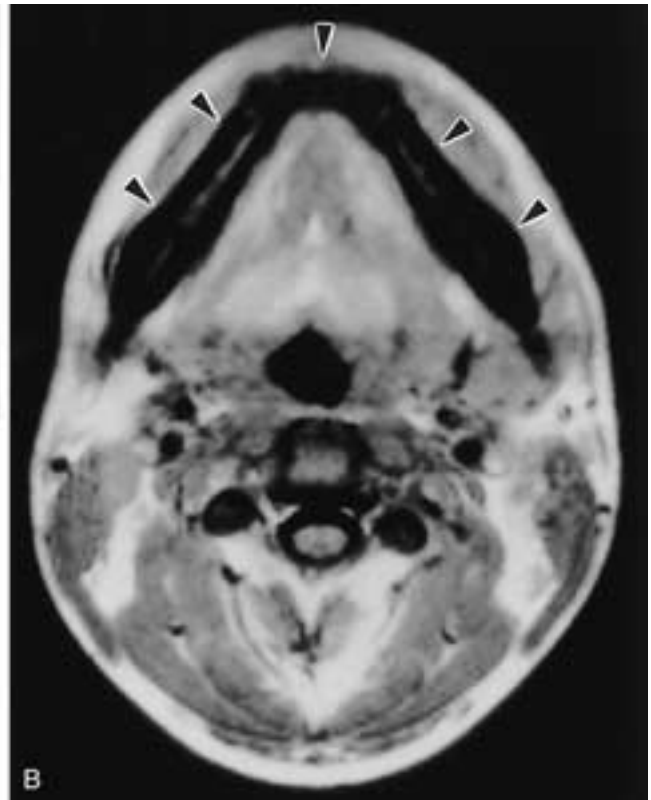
Leukemia of the mandible. A, Periapical film demonstrates general rarefaction and loss of the lamina dura (arrowhead). B, Axial T1-weighted MR image shows diffuse low signal intensity in the entire mandible (arrowheads). Normal fatty marrow has been completely replaced by leukemic infiltration.
